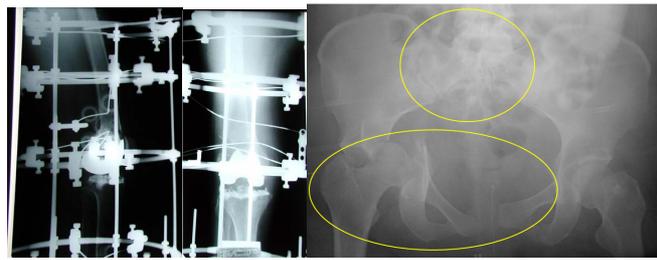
a) Post-operative X-ray snapshot of a patient after the external fixation of a periprosthetic fracture following above the knee arthroplasty; b) Fracture of the pelvis and its acetabulum (anteroposterior radiograph - transverse with posterior wall acetabular fracture).
